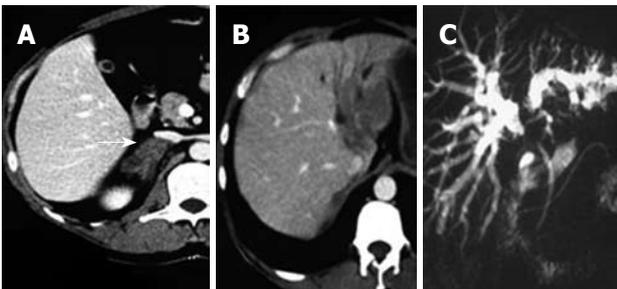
Imaging changes. A: Arrow shows computed tomography (CT) features of adrenal mucormycosis; B: CT features of hepatic lesion. A well circumscribed hypodense lesion in hilar and left lateral lobe, surrounding the vessels without a mass effect, should suggest an angioinvasive organism. This lesion presents necrosis of liver tissue due to fungal thrombosis; C: Magnetic resonance cholangiopancreatography demonstrates an abrupt stenosis of the primary biliary confluence with symmetric upstream dilation of the intrahepatic bile ducts.
